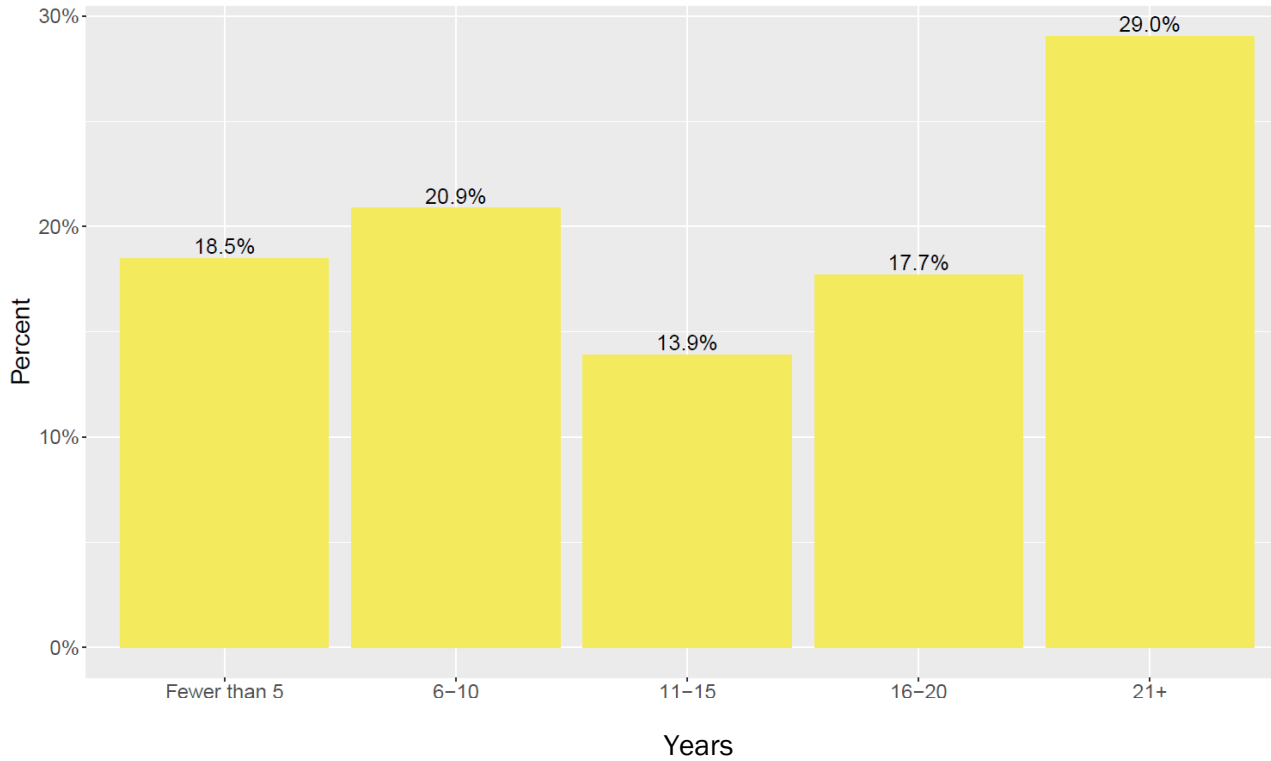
2015 PE Survey Respondents Years Performing Pediatric Echocardiography Ultrasound
